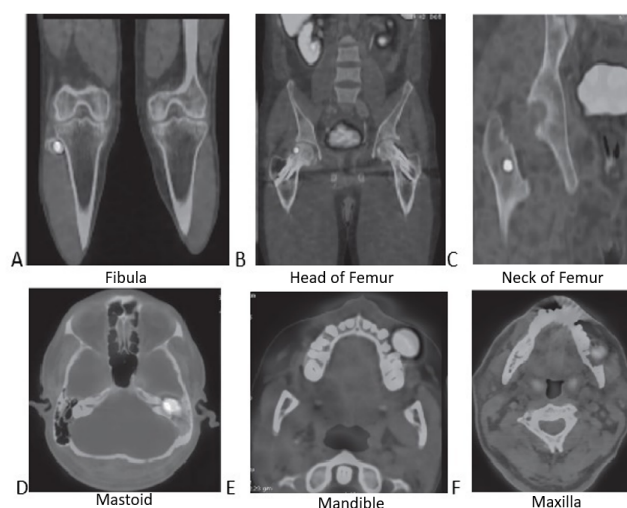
Ga-68 DOTANOC PET/CT of cases showing somatostatin avid lesions: A) fibula, B) head of femur, C) neck of femur, D) mastoid, E) mandible, F) maxilla.
